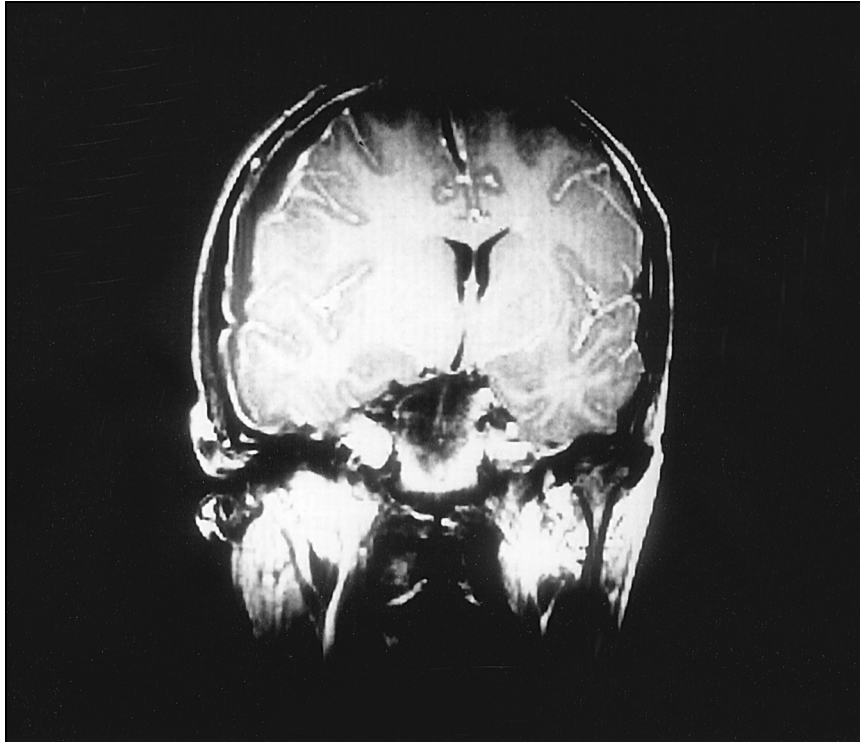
Intracranial subdural hematoma overlying the cerebral convexity. A single frame of the MRI, although documenting the presence of the empyema, gives a false impression of the amount of purulent material present—the empyema extends over the entire cerebral convexity and may contain over 50 mL of pus.
